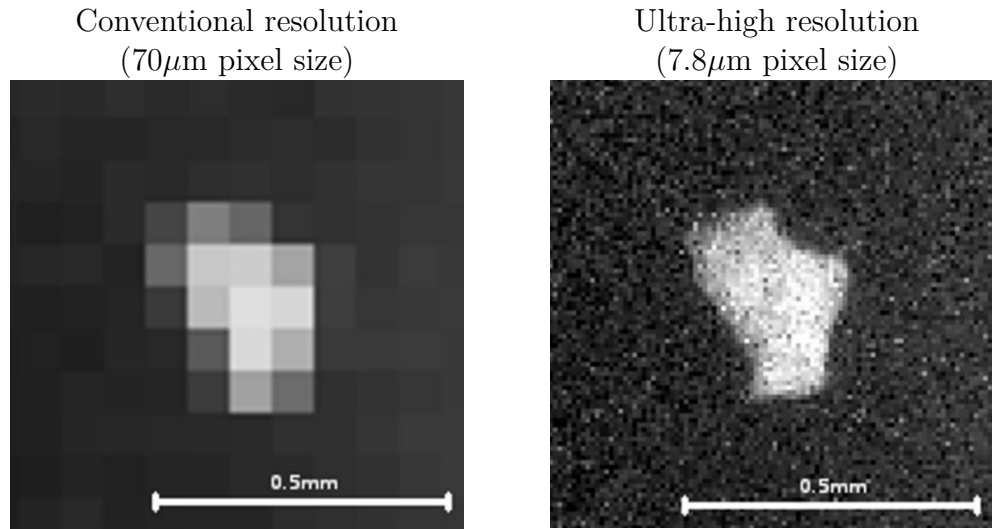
X-ray images of a microcalcification obtained during a breast biopsy shown at current mammography resolution, 0.07mm pixel size (left), and at $10\times$ higher resolution, 0.007mm pixel size (right). There is poor morphological information in the conventional image because only a small number of pixels make up the calcification, whereas higher resolution more clearly shows texture and shape of the calcification.
